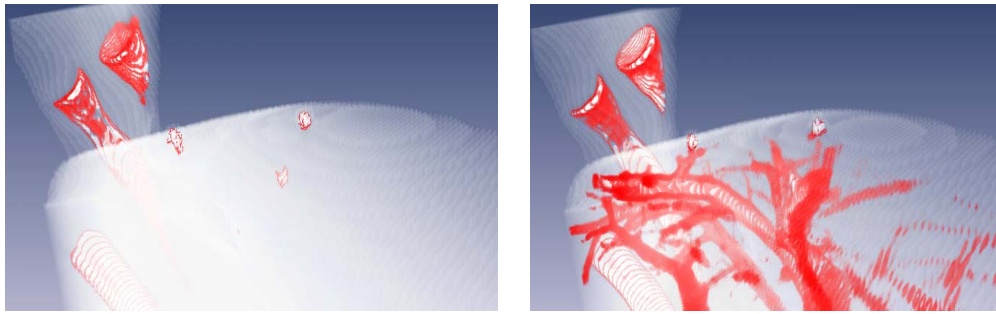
Volume rendering of original intraoperative CT and registered initial CT. Note that the latter shows the vasculature.
